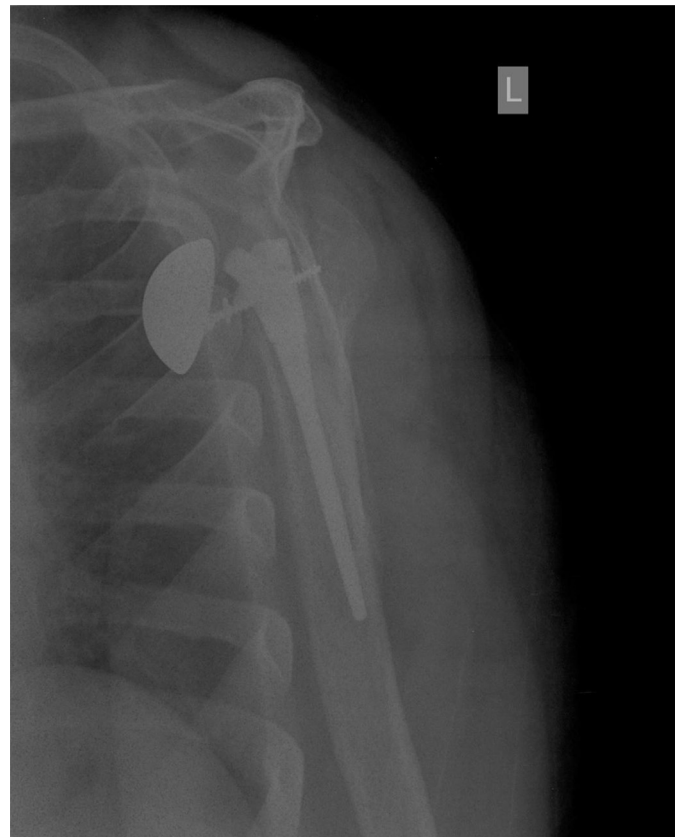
Radiographs showing the humeral head dissociated from the body of the prosthesis.
